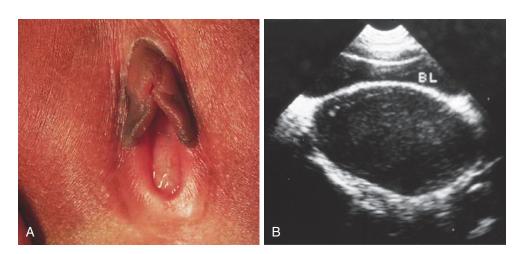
A, Imperforate hymen. Accumulated secretions in the vagina and uterus caused bulging of the hymen and a pelvic mass in this newborn. B, A pelvic mass arising at the expected time of menarche suggests the presence of an obstructed uterine anomaly, here demonstrated by pelvic ultrasound as an oval mass compressing the bladder anteriorly. Urinary anomalies commonly coexist. BL, bladder.
